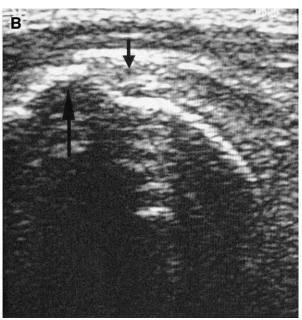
A, Transducer position for longitudinal imaging of the supraspinatus tendon with the shoulder in internal rotation and extension. B, Longitudinal ultrasonic image of the supraspinatus tendon (*short arrow*) with the shoulder in internal rotation/extension including the supraspinatus attachment to the greater tuberosity (*long arrow*).
